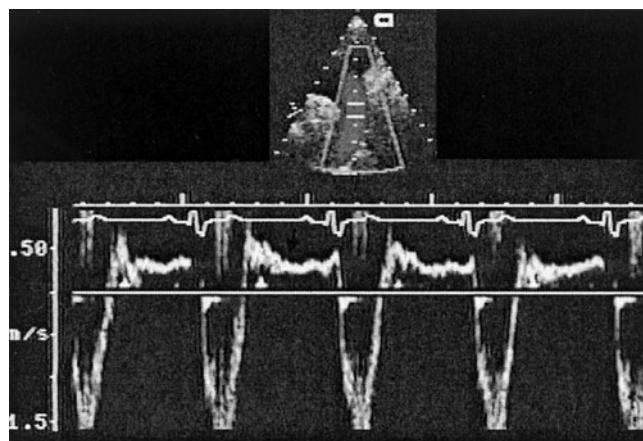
Recording of pulsed-wave Doppler in the high descending aorta in a patient with severe aortic regurgitation. Note during diastole the holodiastolic reversal of flow with high velocity (arrow).
